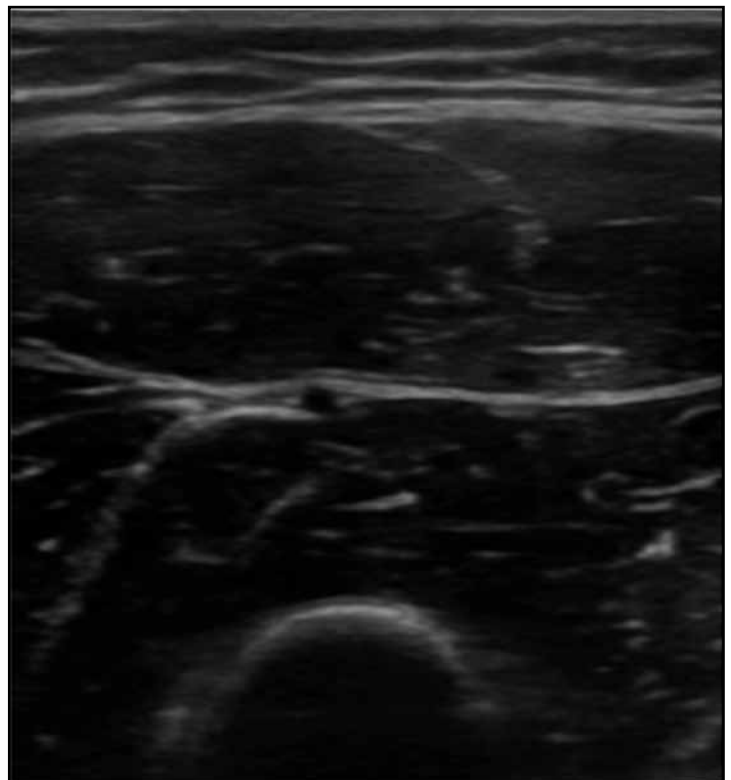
Ultrasound of normal quadriceps muscle showing a 'starry night' pattern.
